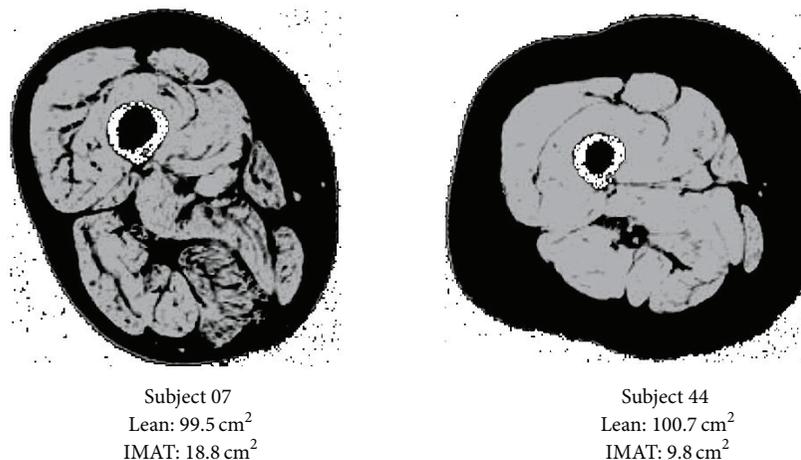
Two women with similar age, BMI, and levels of lean muscle mass but with differing levels of IMAT in a cross-sectional MRI image of the thigh. Subject 7 has double the level of IMAT (black within the muscle) in her thigh as subject 44. While both women have similar levels of lean tissue (seen in grey), they have different levels of mobility and muscle function. The increased levels of IMAT and decreased muscle and mobility function of subject 7 are consistent with literature that reports that increased levels of IMAT are associated with decreased muscle and mobility function.
